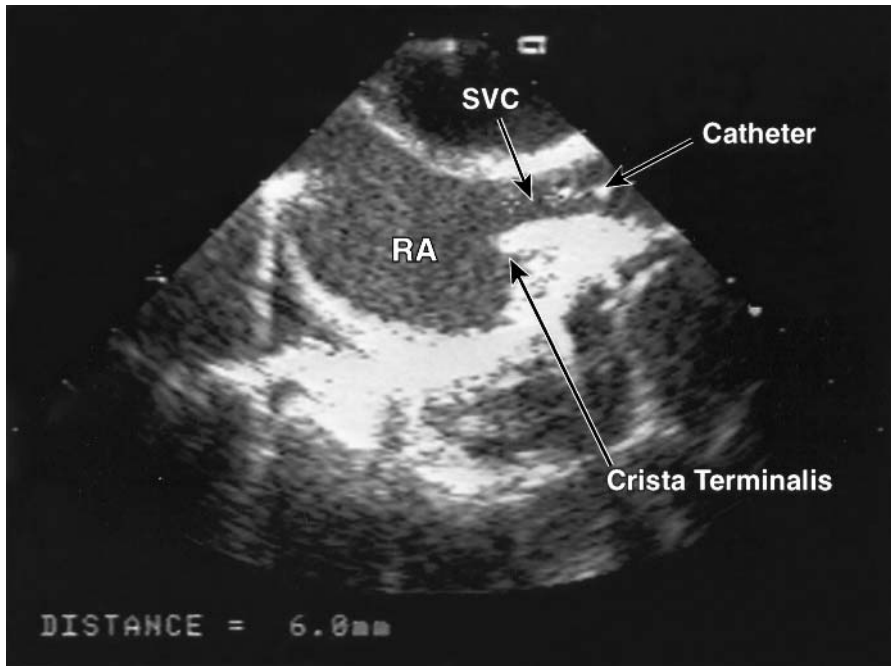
Transthoracic echocardiographic image of the superior vena cava (SVC)–right atrial (RA) junction in sagittal plane in an infant. The tip of the right internal jugular catheter is in the SVC, 6 mm above the RA. Reproduced with permission from Andropoulos DB, Stayer SA, Bent ST. A controlled study of transthoracic echocardiography to guide central venous catheter placement in congenital heart surgery patients. *Anesth Analg* 1999; 89: 65–70.
